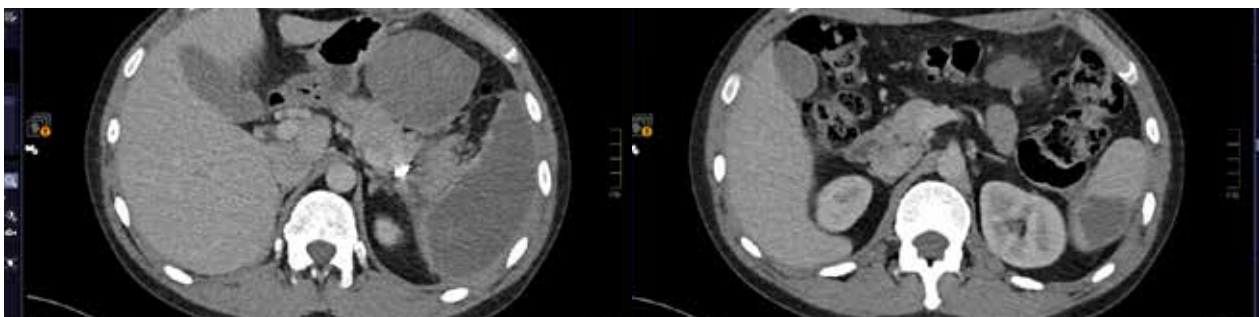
Control CT scan at discharge.*
